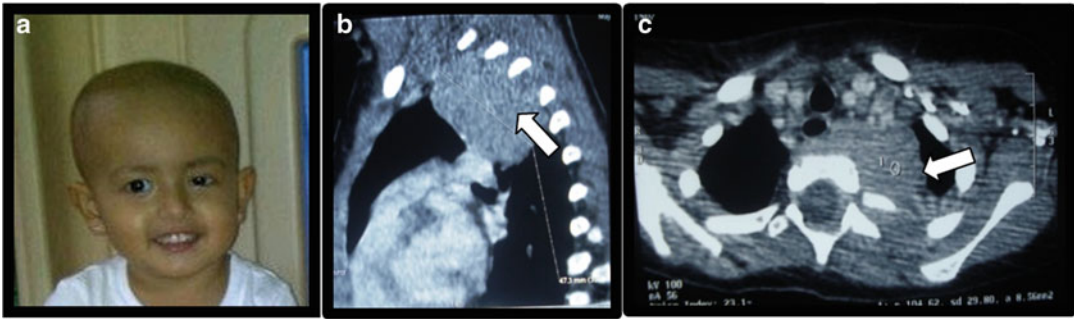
Clinical presentations of neuroblastoma. (a) Evidence of left-sided ptosis in a child with high-level thoracic tumor. This tumor frequently present with Horner's syndrome (ptosis, miosis, and exophthalmos). (b) High thoracic neuroblastic tumors seen on computed tomography (CT scan). (c) Lower thoracic tumors surrounding the airway and likely intraspinal extension noted.
